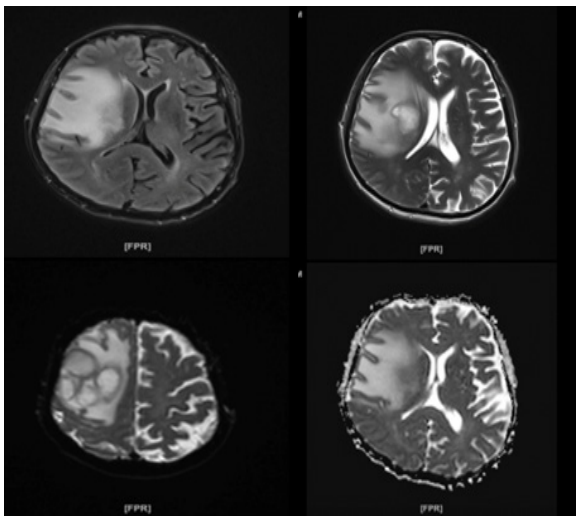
MRI examination of the head with contrast revealed multiple cystic lesions in the right frontoparietal lobe with daughter cysts and surrounding vasogenic edema, suggesting cerebral abscess
